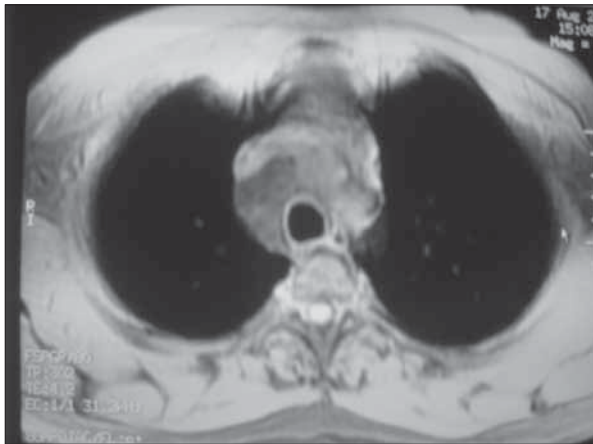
Preoperative chest MRI
